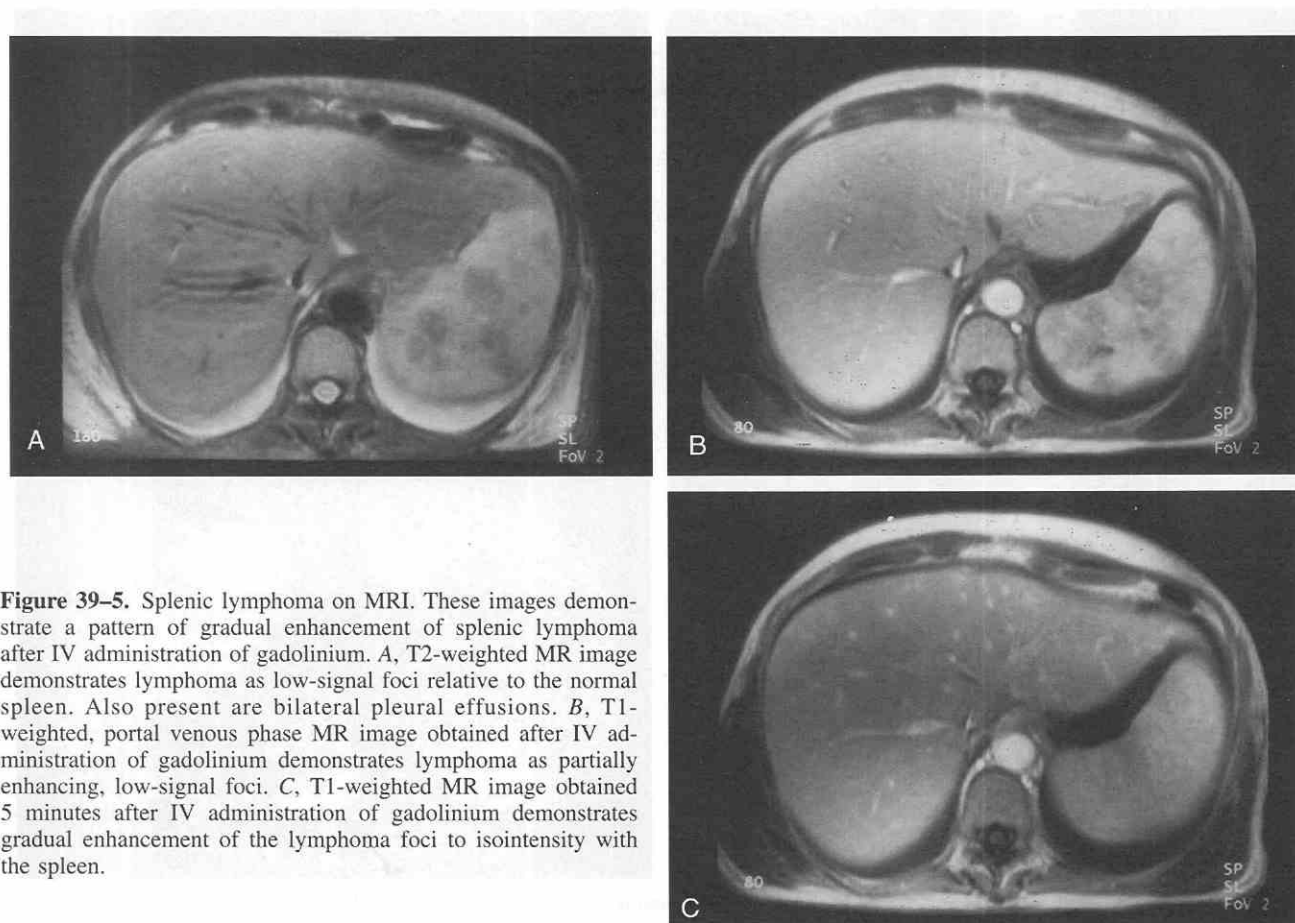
Splenic lymphoma on MRI. These images demonstrate a pattern of gradual enhancement of splenic lymphoma after IV administration of gadolinium. *A*, T2-weighted MR image demonstrates lymphoma as low-signal foci relative to the normal spleen. Also present are bilateral pleural effusions. *B*, T1-weighted, portal venous phase MR image obtained after IV administration of gadolinium demonstrates lymphoma as partially enhancing, low-signal foci. *C*, T1-weighted MR image obtained 5 minutes after IV administration of gadolinium demonstrates gradual enhancement of the lymphoma foci to isointensity with the spleen.
